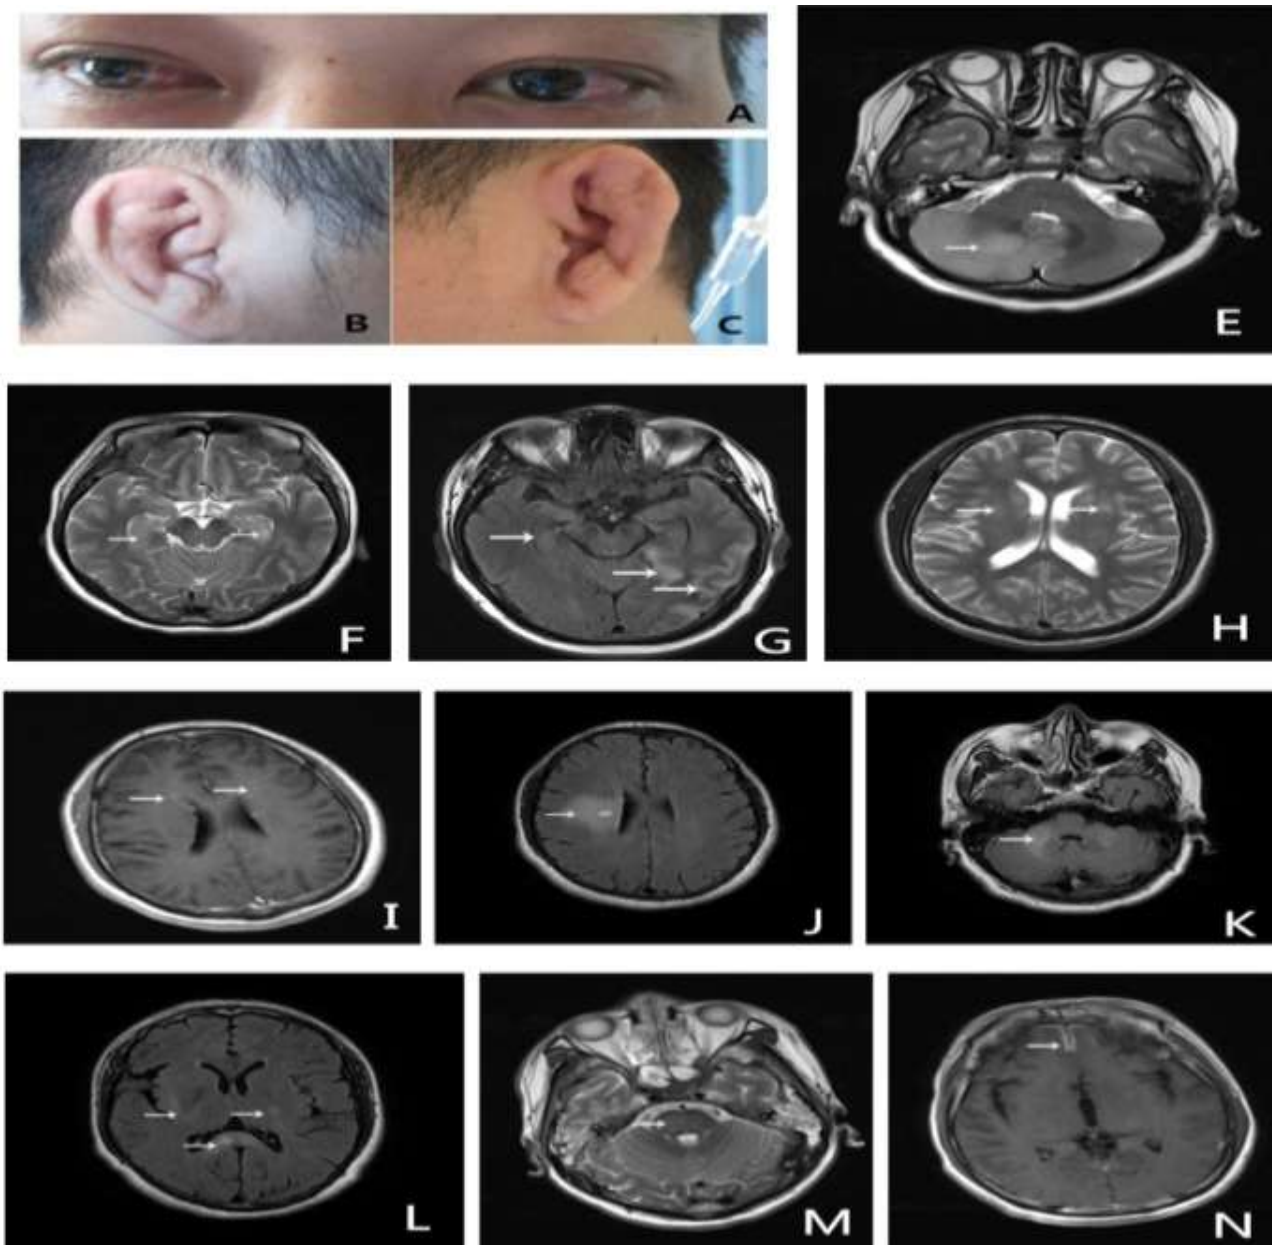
Case 4 showed redness of both eyes (A), redness and swelling of both ears (B, C). Brain MRI showed abnormal signals without enhancement in right cerebellum hemisphere, cerebellum vermis (E: T2W image) and bilateral temporal lobes (F: T2W image) in case 2, abnormal signals in bilateral temporal (G:Flair image), left occipital lobe (D: T2W image; E: Flair image; F: CE image) in case 3, multiple abnormal signals with some enhancement in bilateral basal ganglia (H: T2W image), corona radiate and centrum semiovale (I: CE image) in case 4, abnormal signals with some enhancement in right corona radiate (J), right cerebellum hemisphere (K), corpus callosum (L) in case 6 and abnormal signals in pons (M) and meningeal enhancement in anterior longitudinal fissure (N) in case 7.
